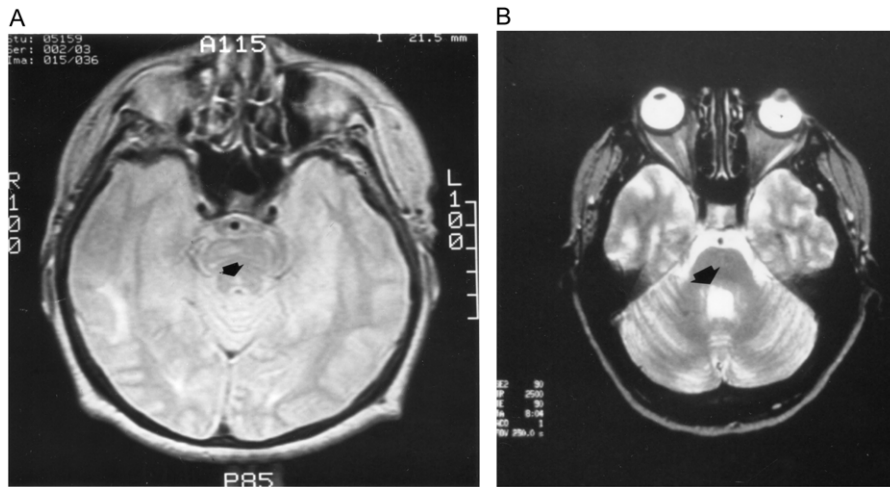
Neuroimaging of exotropic INO patients. (A) MRI scan of Patient 2 shows small hyperintensity in the right pontine tegmentum. (B) MRI of Patient 3 shows T2 hyperintensity in right pontine tegmentum.
